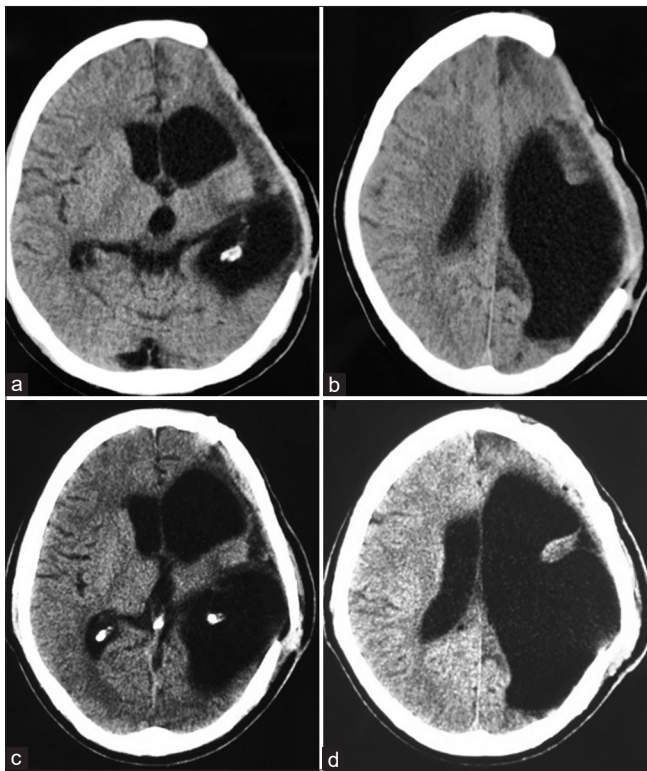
Computed tomography brain plain (a and b) – Postbrain abscess excision shows total excision of the abscess. There is *ex vacuo* dilatation of the ventricular system on the left side. (c and d) – Postcranioplasty computed tomography brain
